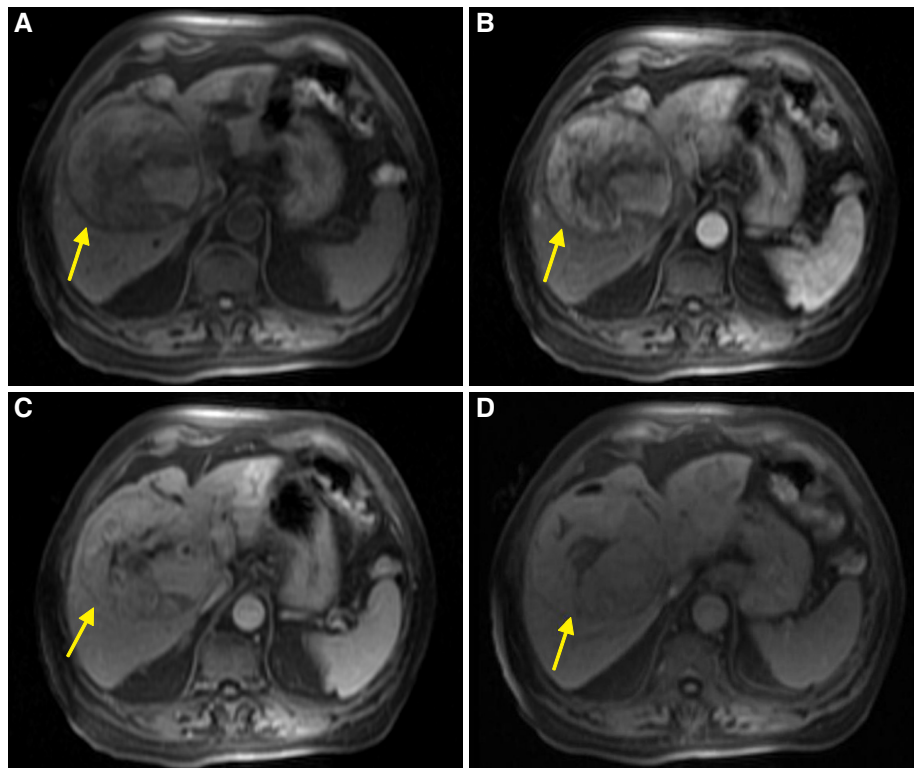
Magnetic resonance imaging of liver acquisition with volume acceleration dynamic sequences in axial planes: empty (A), arterial phase (B), portal phase (C), and delayed phase (D). Non-cirrhotic liver shows mass in the right hepatic lobe (yellow arrows) with necrotic component that presents heterogeneous enhancement in the arterial phase (B), and wash-out in portal phase (C) and delayed phase (D). These findings are compatible with hepatocellular carcinoma with typical behaviour
